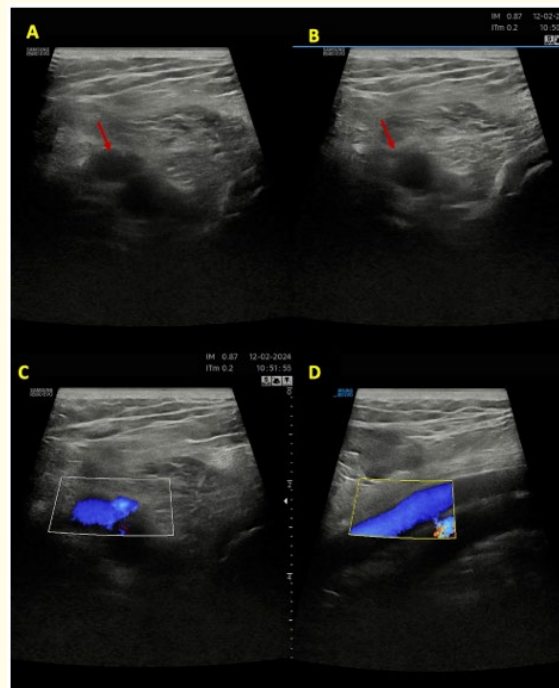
Ultrasound in B-mode and color Doppler of the right popliteal region: (A) Right popliteal vein in B-mode ultrasound displaying anechoic content (Arrow). (B) Popliteal vein compressible after compression maneuver by the ultrasound probe (Arrow). Color Doppler ultrasound images of the popliteal vein in transverse (C) and longitudinal (D) sections demonstrating patency with color Doppler signal. Note the absence of any popliteal cyst formation, which could suggest a Baker’s cyst.
